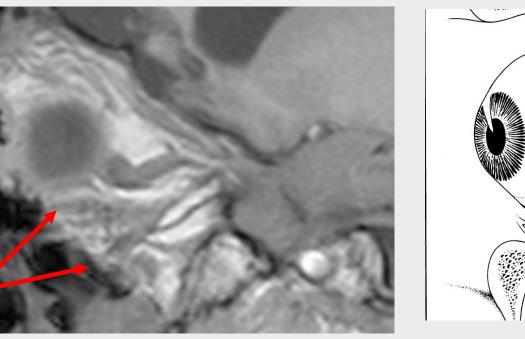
Patient presented with left hypertropia and limited depression of his left eye (yellow arrows) following trauma. MRI demonstrates disruption of the right inferior rectus (red
